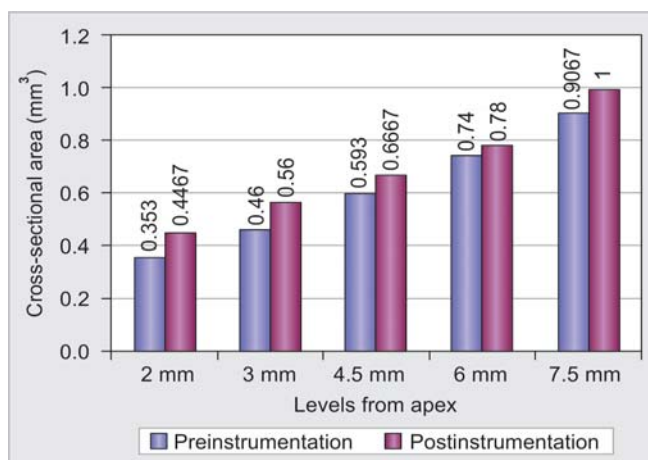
Sample prepared with ProTaper Rotary Preinstrumentation cross-sectional area at predetermined levels from the apex (CT scan)
